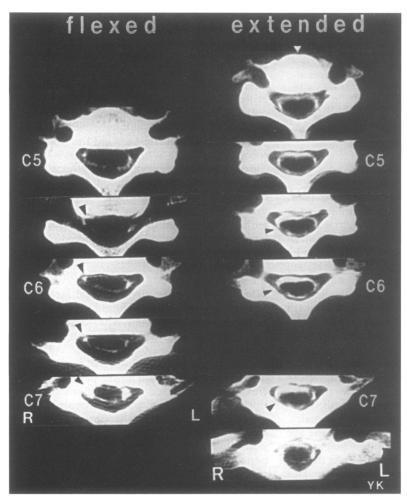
CT myelograms of case No 1 (the affected side is on the right). In neck extension, the lower cervical cord is shifted laterally to the right. Cuneiformed atrophic cord is seen on the affected side (arrow heads). The anterior subdural space is filled more with the contrast medium as the cord is moved posteriorly. In neck flexion, the cord is shifted anteriorly, sharply pulled to the affected side (arrow heads), and flattened anterposteriorly. As the posterior wall of the dural sac shifts anteriorly, the posterior epidural space expands.
